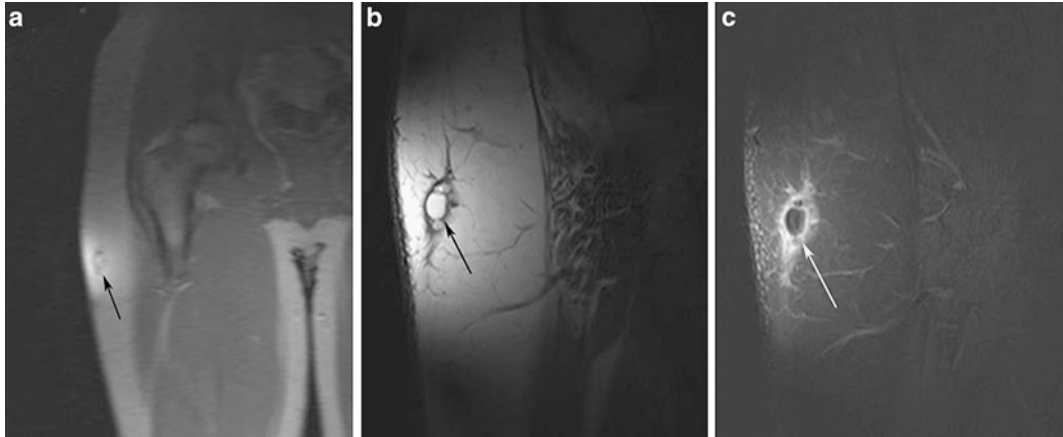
Imaging of the right hip in a 15-year-old male with enlarging mass along the lateral aspect of the hip. (a) Initial GR localizer sequence through the right hip demonstrated a lesion confined to the superficial fat of the right upper thigh. A small surface coil (loop coil) was selected based on the superficial nature of the lesion. (b) T1-weighted image through the lesion demonstrated a
